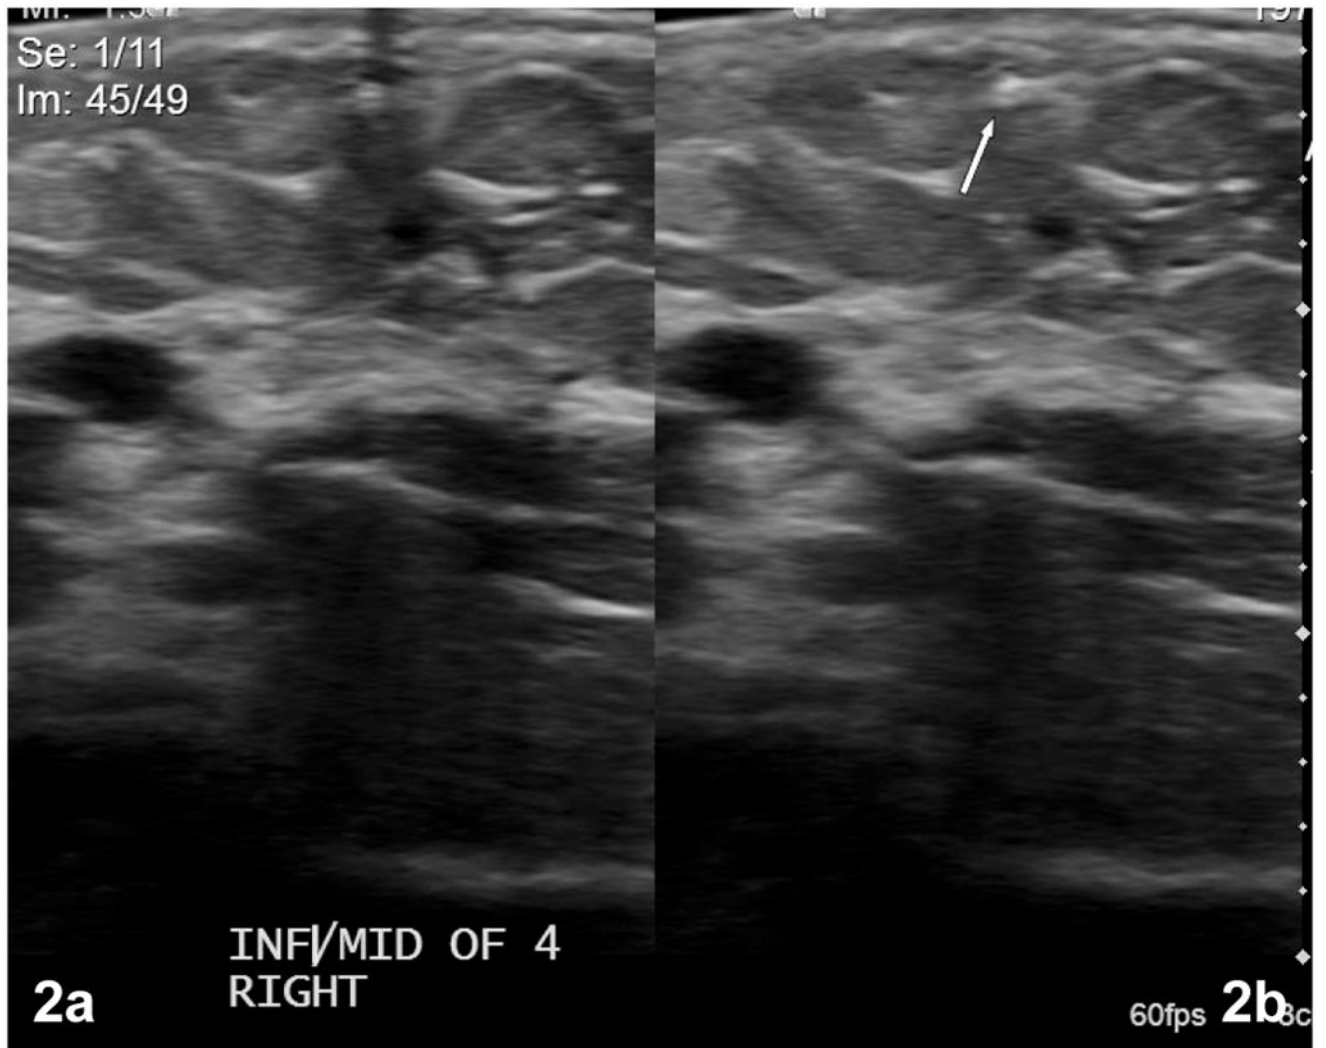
Ultrasound images of a palpable cord located in the axilla of a 38 year old woman. (a) The white dot near the center of the top of the image is the Jelco on the skin surface, below which shadowing is clearly seen. (b) The arrow indicates a hyperdense structure in the tissue under the marker.
